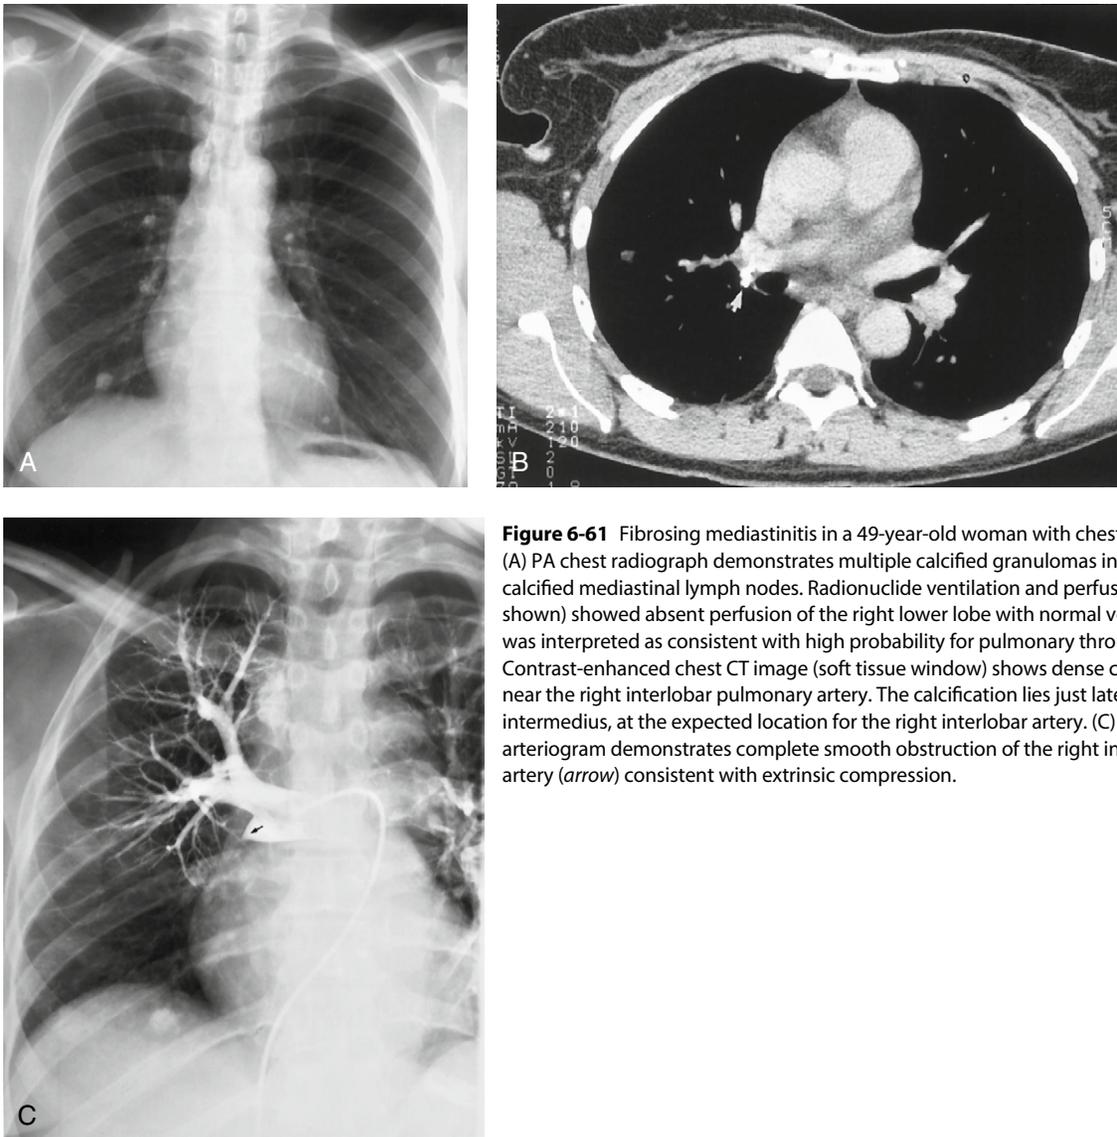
Fibrosing mediastinitis in a 49-year-old woman with chest pain for 4 weeks. (A) PA chest radiograph demonstrates multiple calcified granulomas in the lung and calcified mediastinal lymph nodes. Radionuclide ventilation and perfusion lung scans (not shown) showed absent perfusion of the right lower lobe with normal ventilation. The study was interpreted as consistent with high probability for pulmonary thromboembolism. (B) Contrast-enhanced chest CT image (soft tissue window) shows dense calcification (arrow) near the right interlobar pulmonary artery. The calcification lies just lateral to the bronchus intermedius, at the expected location for the right interlobar artery. (C) Right pulmonary arteriogram demonstrates complete smooth obstruction of the right interlobar pulmonary artery (arrow) consistent with extrinsic compression.
